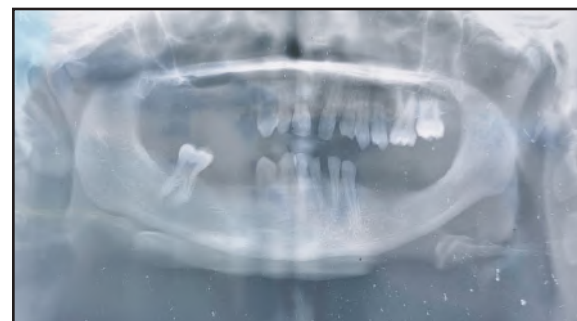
Panoramic X-ray (OPG) reveals
